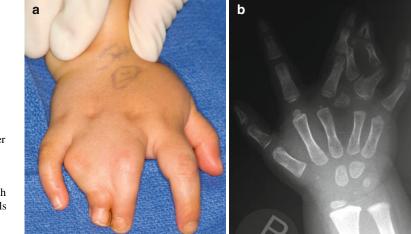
2 year-old with syndactyly combined with duplication of the ring finger (synpolydactyly) (Courtesy of Shriners Hospital for Children, Philadelphia). (a) Dorsal view of hand with syndactyly. (b) X-ray reveals ring finger duplication with awkward interconnections
